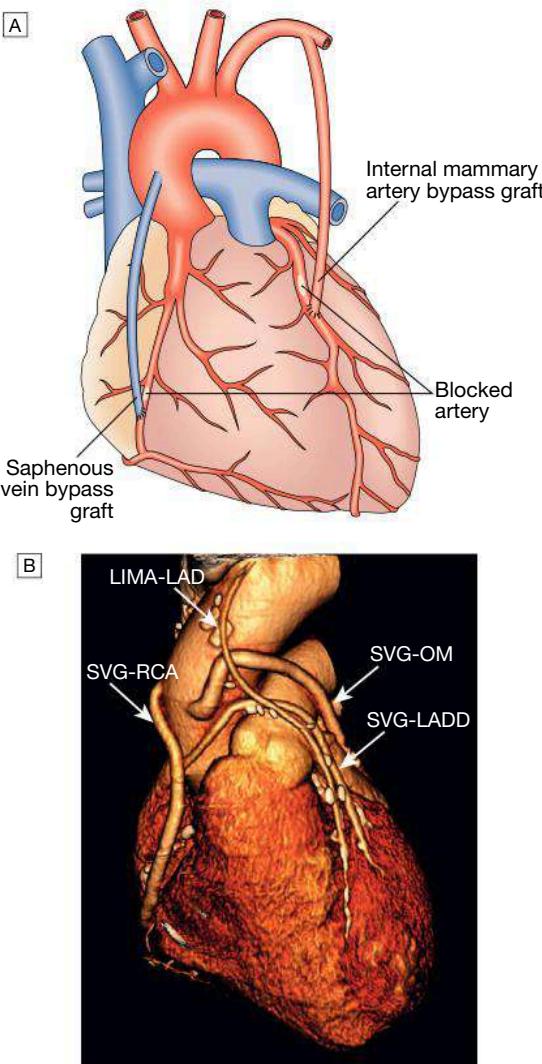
Coronary artery bypass graft surgery. A Narrowed or stenosed arteries are bypassed using saphenous vein grafts connected to the aorta or by utilising the internal mammary artery. B Three-dimensional reconstruction of multidetector CT of the heart. The image shows the patent saphenous vein grafts (SVG) to the right coronary artery (RCA), obtuse marginal branch (OM) and diagonal branch (LADD), and left internal mammary artery graft (LIMA) to the left anterior descending (LAD) coronary artery.
